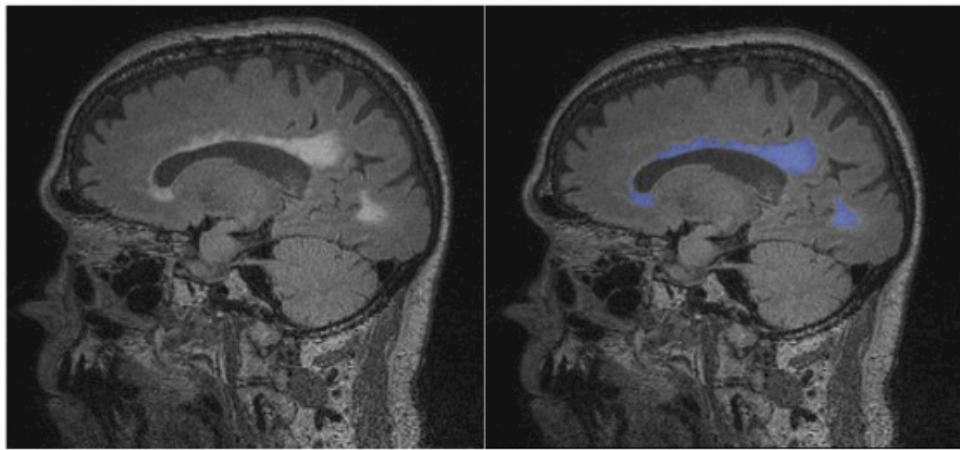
Sagittal slice of T2-FLAIR showing white matter hyperintensity (left). The blue mask overlying WMH (right) is created in Quantomo (Cybertrial, Inc: Calgary, Canada), which calculates a lesion volume based on the marked boundaries.
